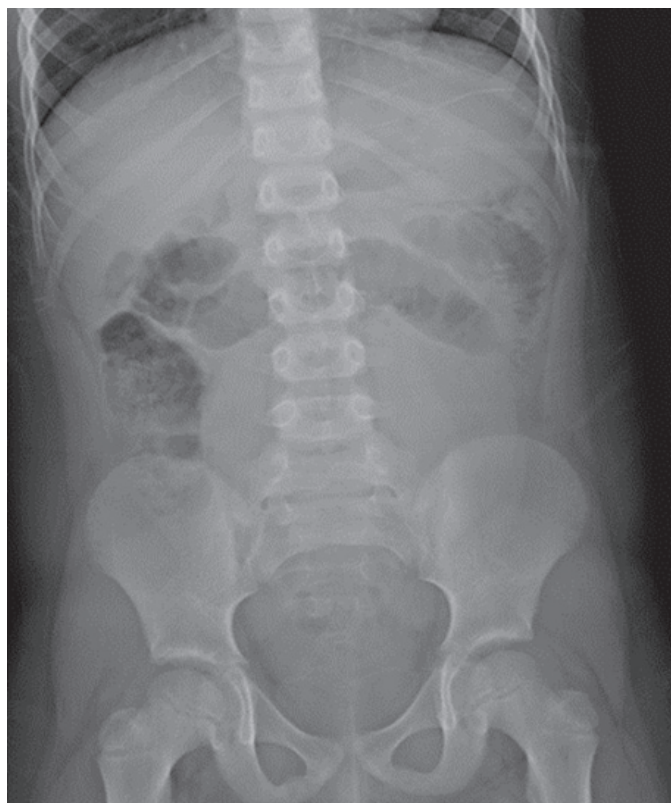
Abdominal plain X-ray showed dilated loops of bowel containing gas but the findings were nonspecific for intestinal obstruction or ileus.
